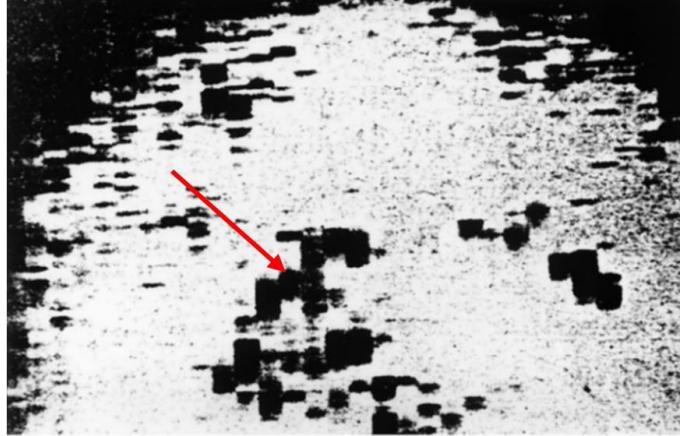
First diagnostic ultrasound image of a living human brain [24]. Red arrow indicates ventricles.
